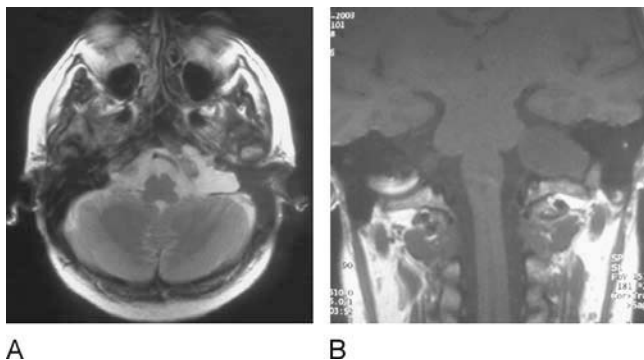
MRI images showing a jugular fossa chondrosarcoma. A) Axial section and T1-weighted sequence with contrast which shows the presence of a mass of 3 cm in diameter, centered in the left jugular fossa. B) A slight compression of the middle cerebellar peduncle caused by chondrosarcoma is evident in the coronal plane and T1, along with a subarachnoid cleavage plane between the two structures. Note the independence and indemnity of the ipsilateral sigmoid sinus.
